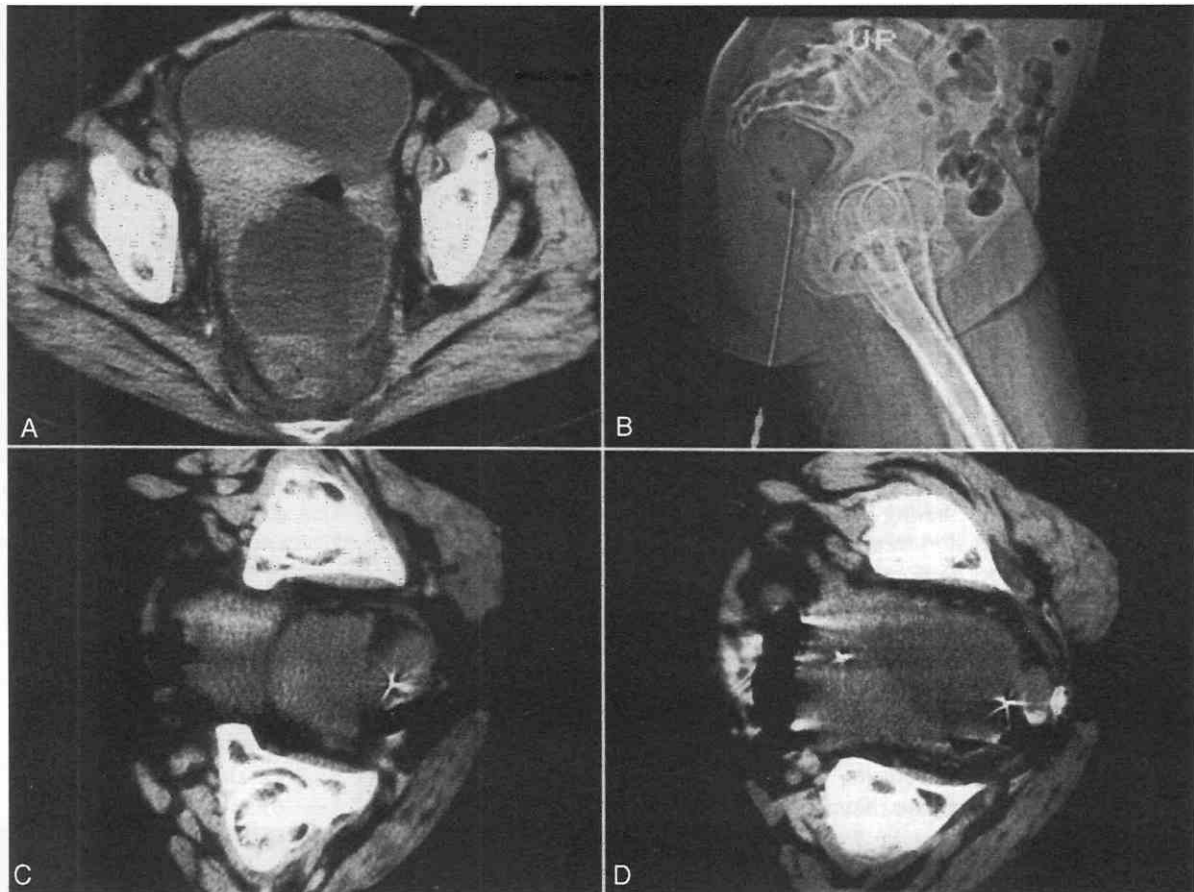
A*, CT scan shows a large abscess between the uterus and rectum, which was drained by a transrectal drainage. *B*, Topogram shows a needle being inserted by means of the rectum, through the plastic tube as noted in Figure 61-131. *C*, CT scan over the lower pelvis shows the needle in the rectum. Compared with the first image in *A*, the needle was correctly angled to enter the cavity. *D*, Lowest CT scan over the pelvis shows the needle entering the abscess cavity. With the use of the topogram, the angiographic wire and catheter were inserted.
